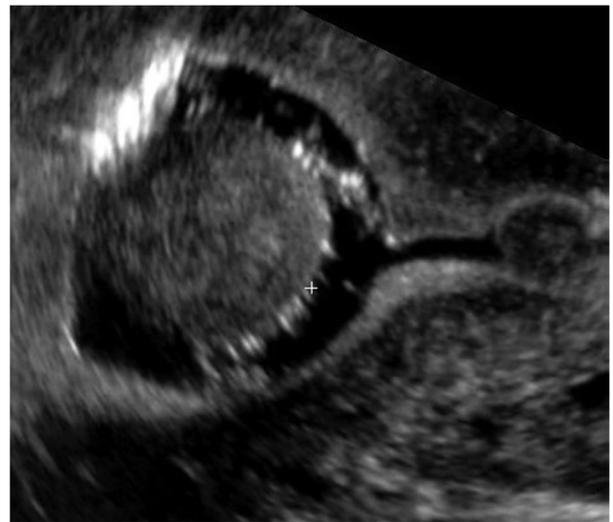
Saline infusion sonography demonstrating a 30×30 mm intracavitary uterine fibroid, protruding from the fundus.
